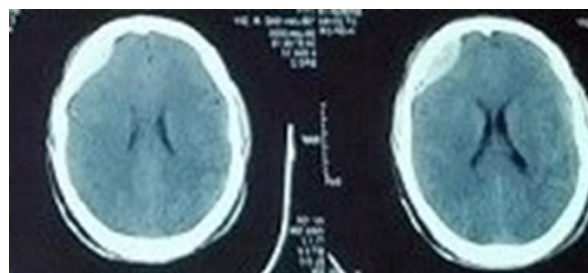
CT brain scan showing the extradural hematoma.
